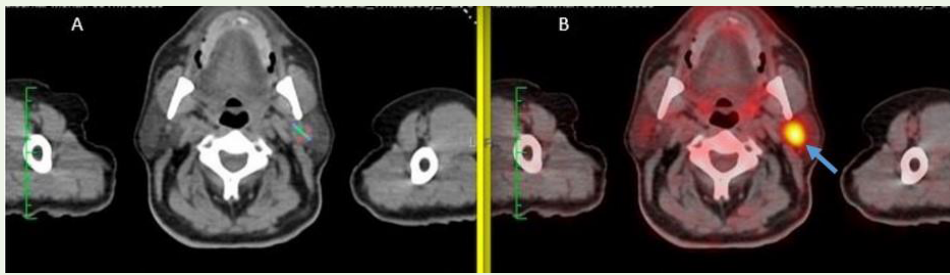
Image A and B: FDG PET-CT scan showing an FDG avid lesion in the left parotid gland.
